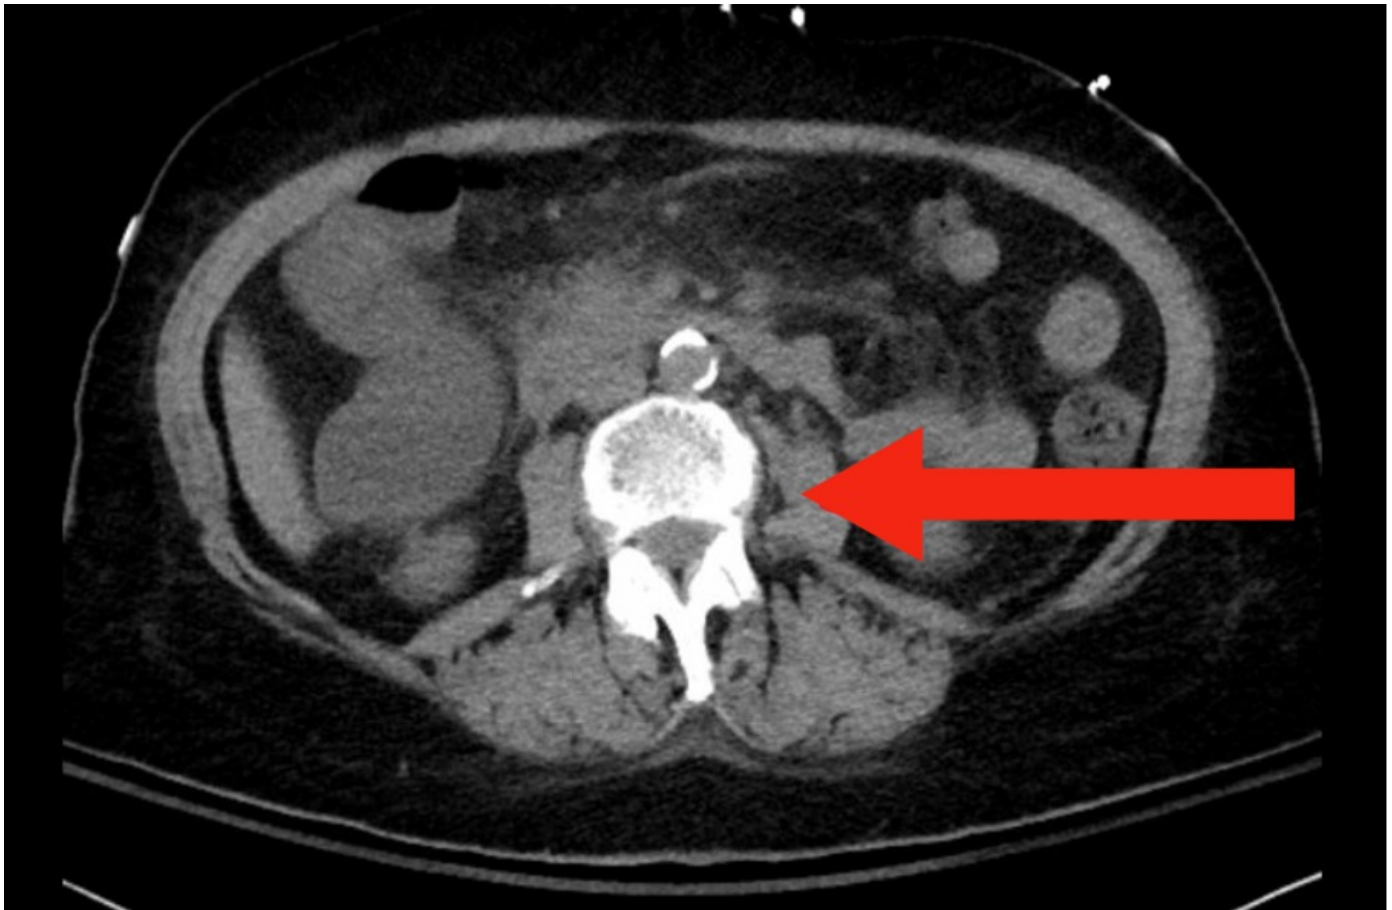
CT Abdomen Pelvis with contrast demonstrating soft tissue densities along the bilateral retroperitoneal lining, suggestive of reactive lymphadenopathy.
